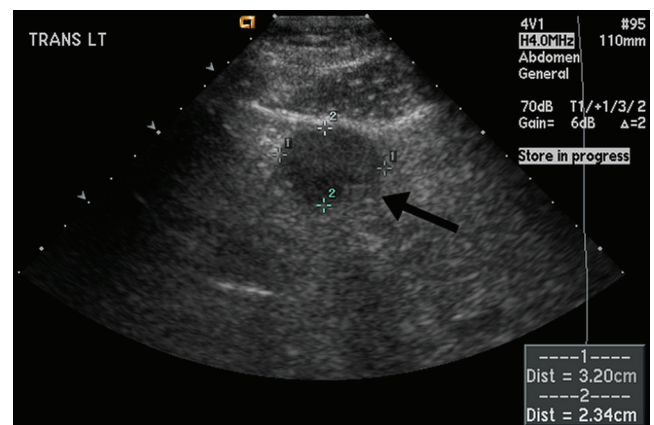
Screening ultrasonography shows a 3.2-cm hypoechoic mass (arrow) along the hepatic capsule.
